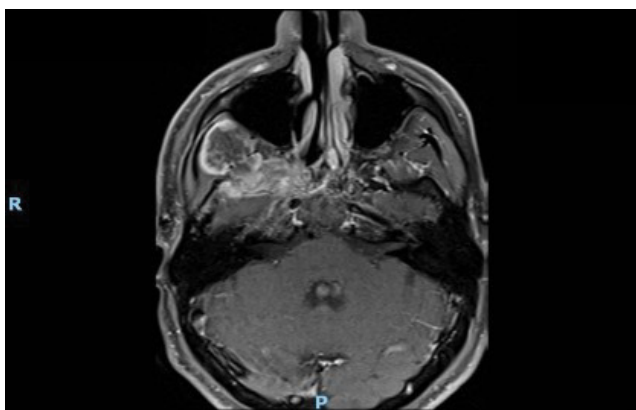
MRI pre-operative axial T1 image.
